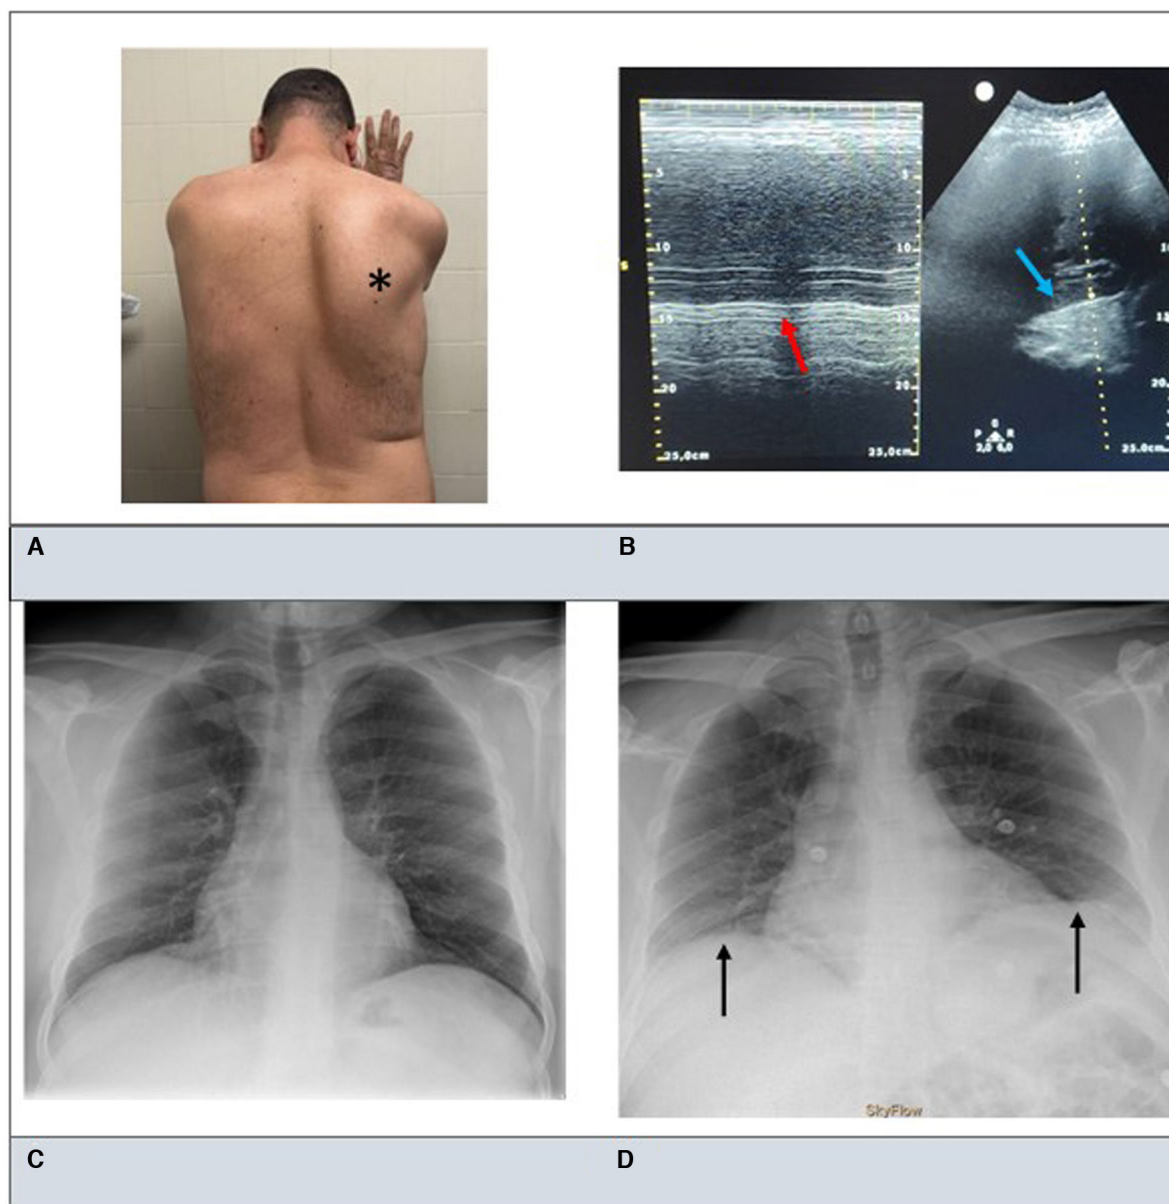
Bilateral diaphragmatic paralysis due to HEV-associated neuralgic amyotrophy. (A) Right winged scapula on physical examination (black asterisk). (B) Lung ultrasound of the right diaphragm showing a quiet breathing excursion of approximately 0.5 cm (normal values for right diaphragmatic excursion in men range from 0.9 to 2.8 cm during quiet breathing). The red and blue arrows indicate the right hemidiaphragmatic excursion in M-mode and B-mode ultrasonography, respectively. (C) Chest X-ray taken 5 years before symptom onset. (D) Chest X-ray taken on the same day of hospital admission, revealing elevation of both diaphragms (black arrows).
